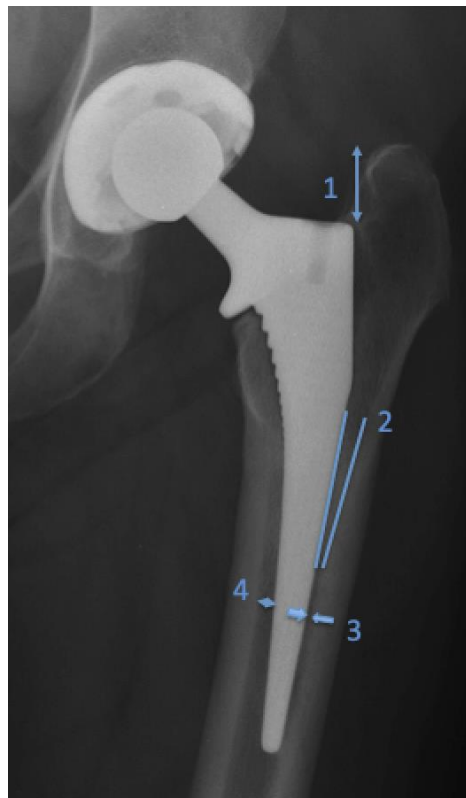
Radiographic analysis parameters
